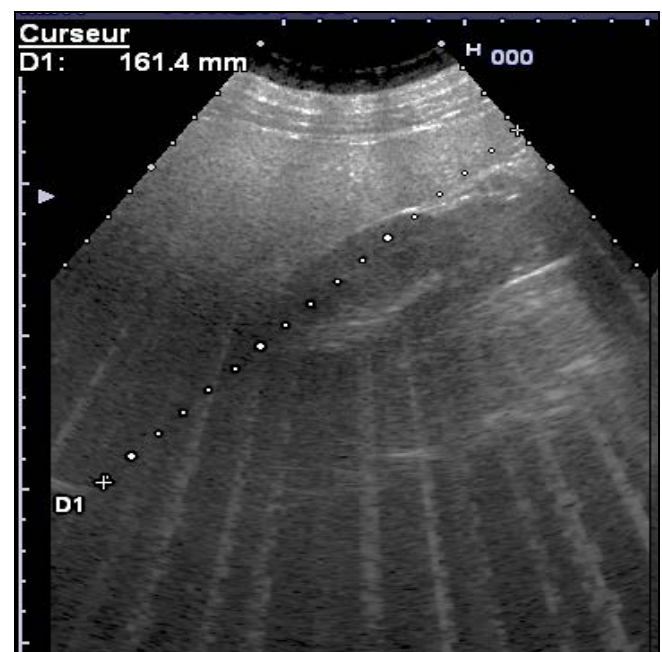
Longitudinal ultrasound section of the liver: showing an increase in the hepatorenal echogenicity gradient with deep ultrasound attenuation in favor of severe steatosis
